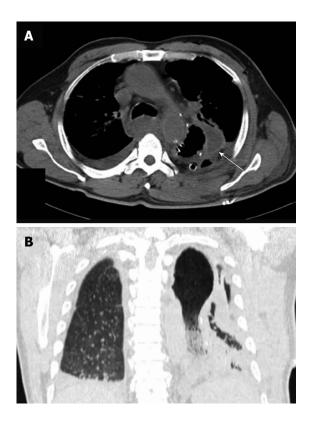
Computed tomography scan. A: Axial computed tomography (CT) imaging of the chest: The CT scan showed a remarkably distended thoracic stomach and a locally thickened gastric wall (arrow); B: Coronal CT scan of the chest: Imaging revealed a thoracic stomach with a large consolidation shadow and in air bronchograms of the left lung, pleural and pericardial effusions were also suggested.
